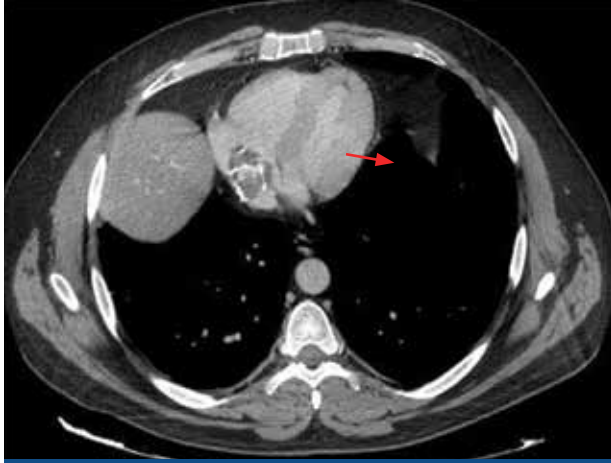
Cardiac computed tomography confirmed mass (thrombus) in the right atrium extending into the inferior vena cava.
